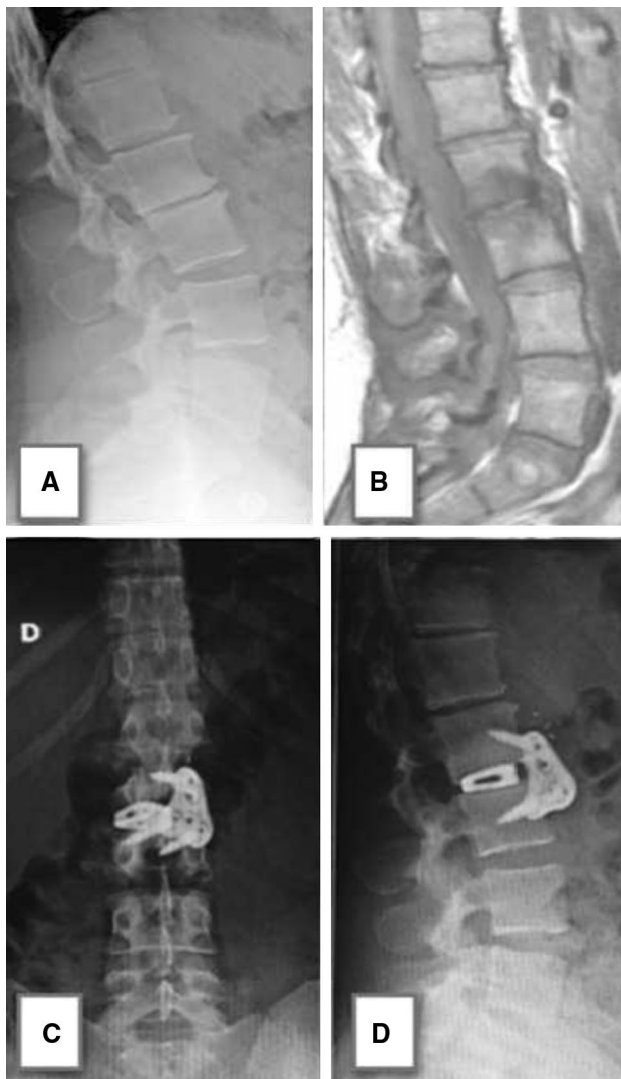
a, b X-ray lateral view and sagittal T1-weighted MRI scan showing L2–L3 DDD with loss of segmental lordosis. c, d Postoperative X-rays in AP and lateral position demonstrating the L2–L3 cage insertion through OLIF approach and stabilization by plate. Restoration of segmental lordosis was 5°
